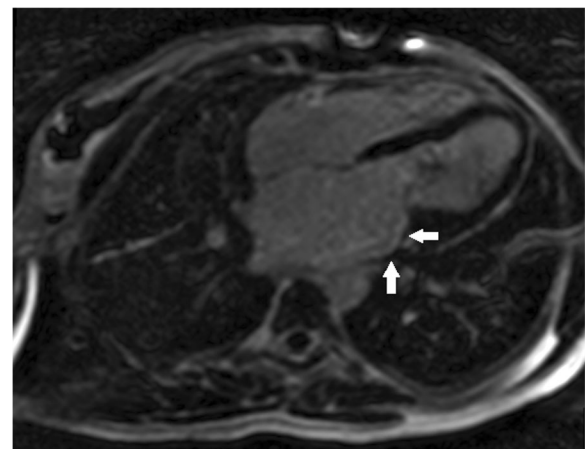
DE-MRI showing mild atrial fibrosis (involves a part of the posterior wall of the left atrium, arrows)
